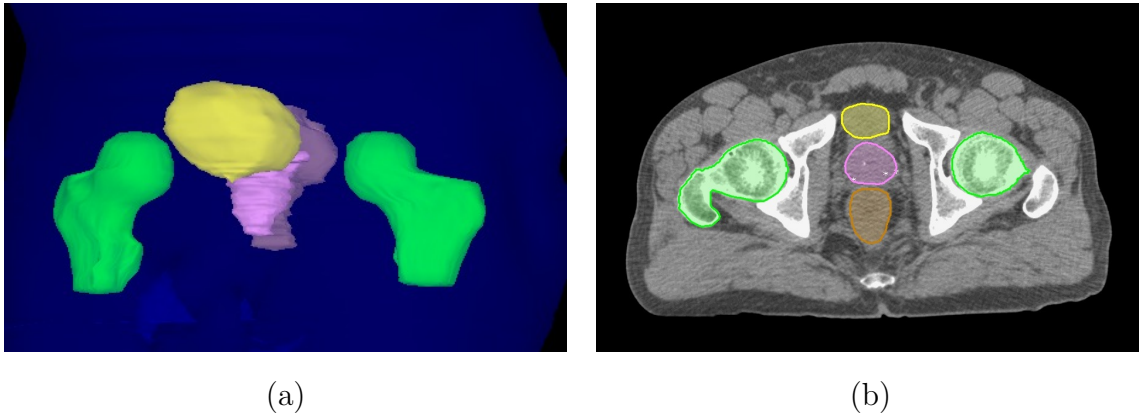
(a): 3D geometry of a prostate cancer patient; (b): one CT slice of the same patient
